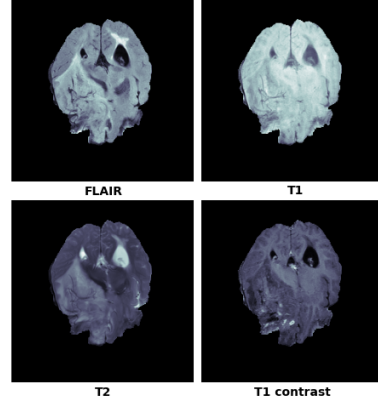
Example of an MRI scan with FLAIR, T1, T2 and T1 contrast-enhancing.
